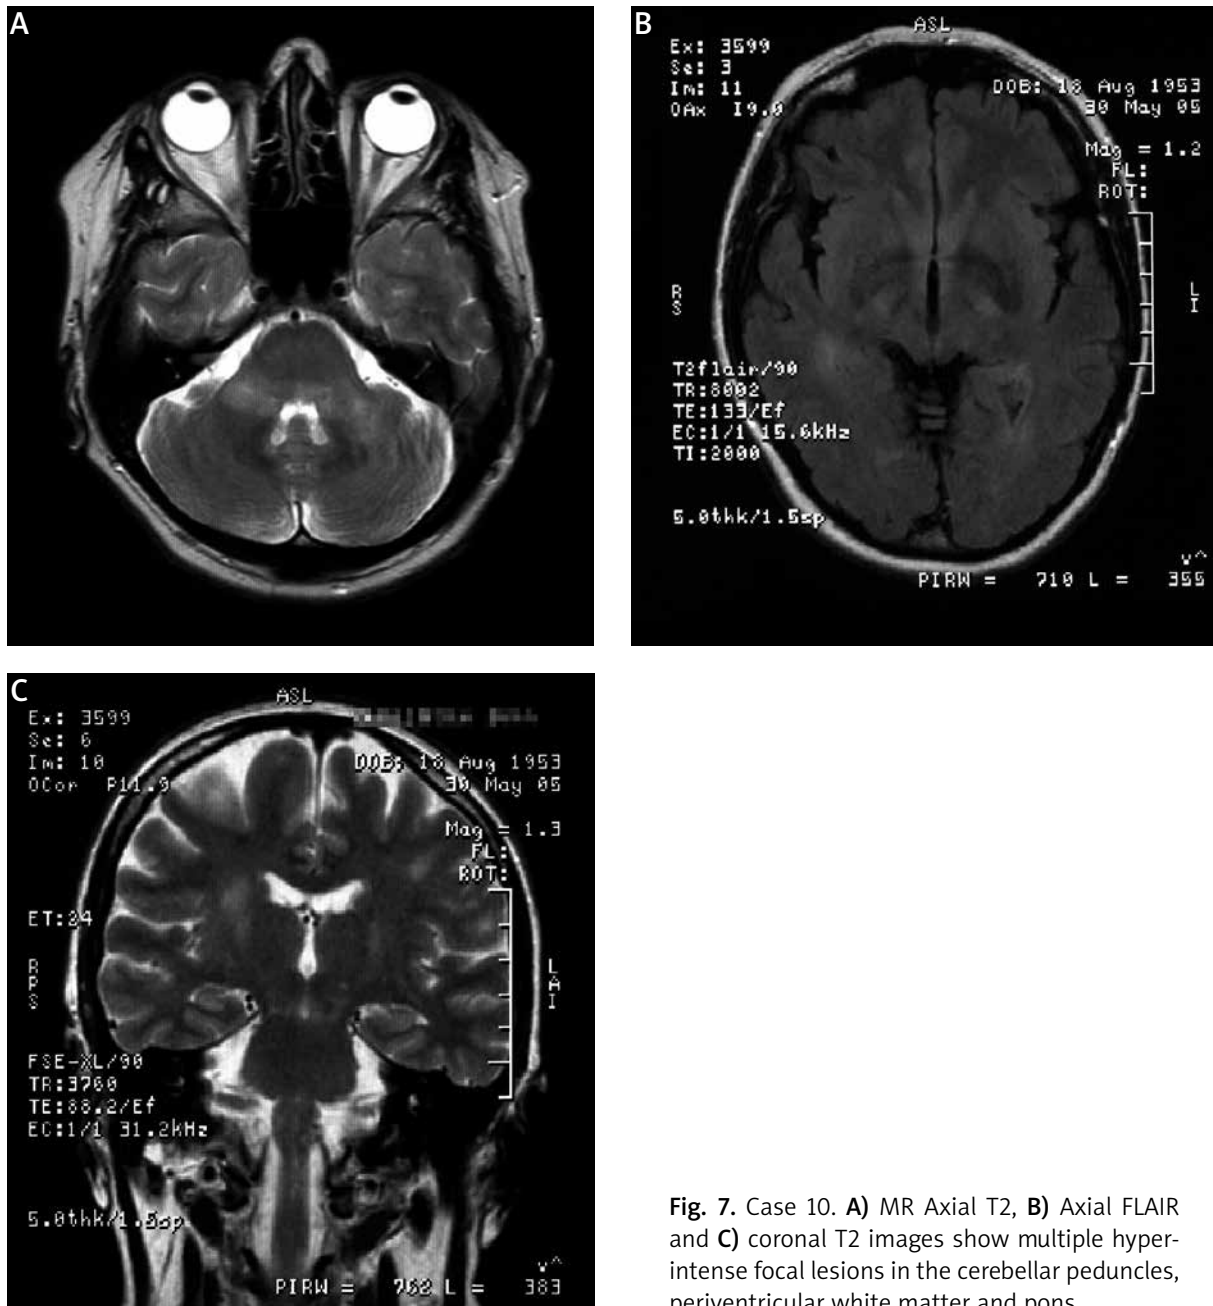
Case 10. A) MR Axial T2, B) Axial FLAIR and C) coronal T2 images show multiple hyperintense focal lesions in the cerebellar peduncles, periventricular white matter and pons.
